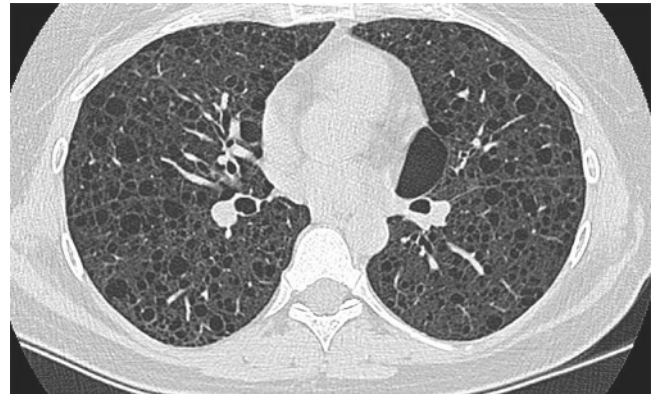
Chest computed tomographic scan showing diffuse cystic change in a patient with lymphangioleiomyomatosis.
